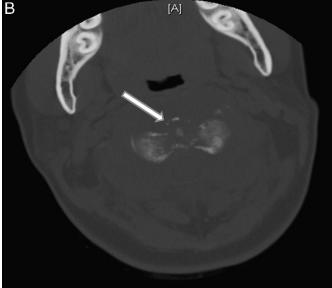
(A) Sagittal reconstruction computed tomographic scan of the cervical spine showed permeative lytic destruction of the dens and body of C2 with narrowing of the spinal canal and compression of the cord at that level. Also noted was an adjacent soft-tissue component extending into the prevertebral soft tissues and a pathologic fracture with complete disassociation of the dens from the body of C2 without significant displacement (arrow). (B) Axial computed tomographic scan of the cervical spine showed destruction of the odontoid with a pathologic fracture through the base of the dens.
